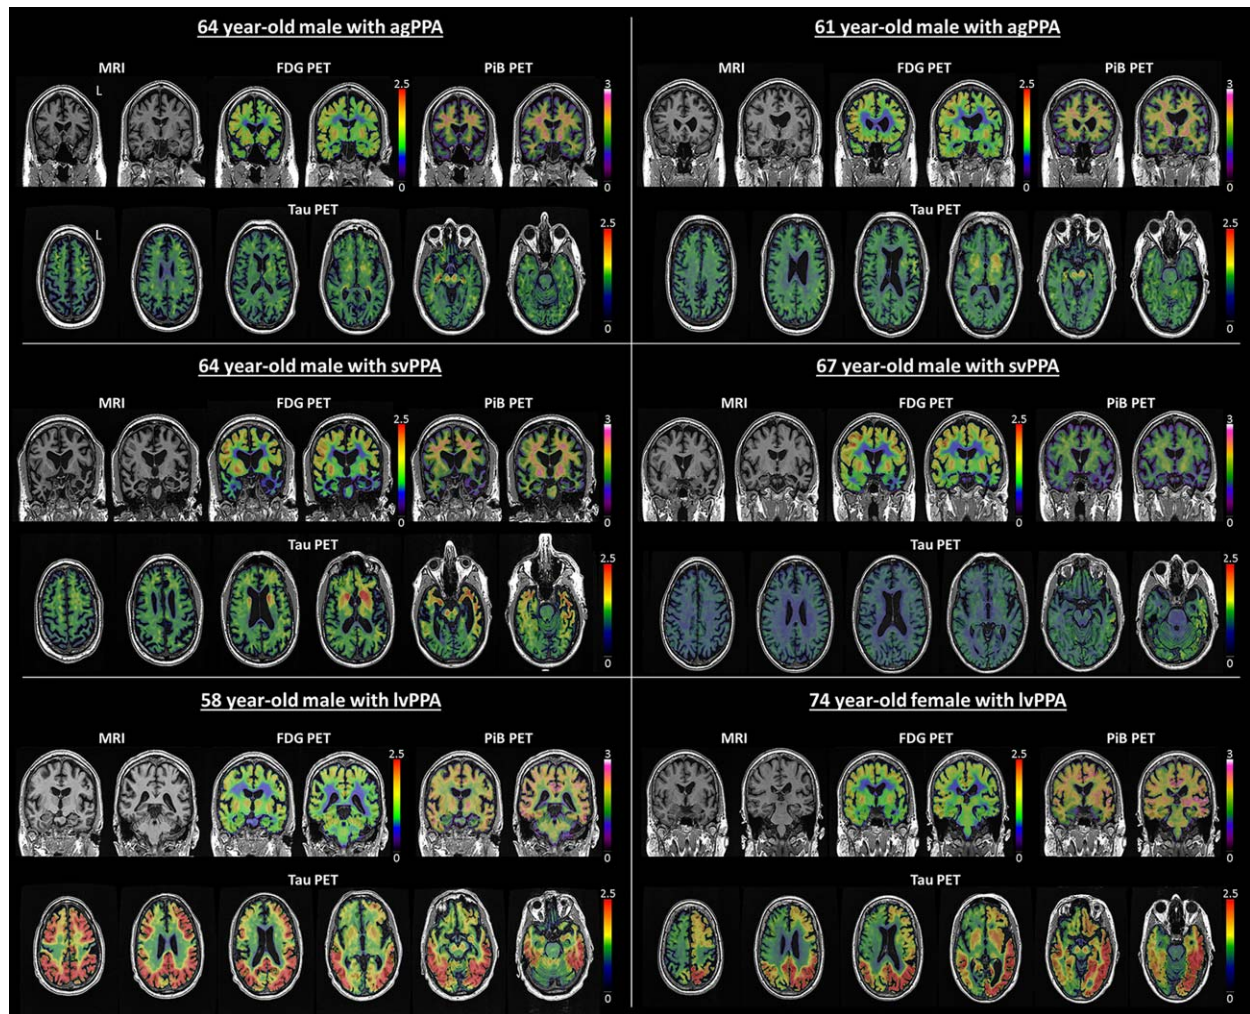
Individual [^{18}F]AV-1451 tau-PET, FDG-PET, PiB-PET, and MRI images from 2 agPPA, 2 svPPA, and 2 lvPPA subjects. Scales represent SUVR. FDG = fluorodeoxyglucose; MRI = magnetic resonance imaging; PET = positron emission tomography; PiB = Pittsburgh compound B; PPA = primary progressive aphasia; agPPA = agrammatic/nonfluent variant; lvPPA = logopenic variant; svPPA = semantic variant; SUVR = standard uptake value ratio.
